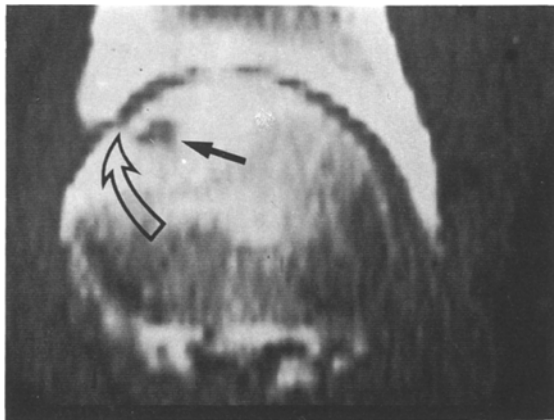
Ischaemic necrosis of the femoral head. Reformatted image in the sagittal plane reveals characteristic increased density of the weight-bearing aspect, in association with a subchondral cyst (*straight arrow*) and subtle collapse of the articular surface (*curved arrow*). The latter finding was not evident on conventional radiographs
